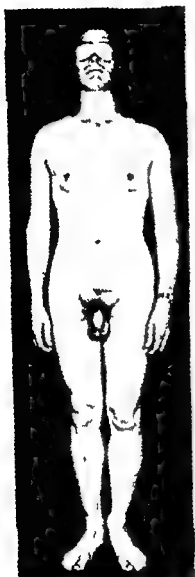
CHROMOPHOBE TUMOR (See Protocol 4 \ Fig 50) Treatment with roentgen therapy testosterone and chorionic gonadotropin The last caused rapid enlargement of breasts With absence of tubular function gynecomastia may have resulted by factors postulated in Klinefelter's syndrome
